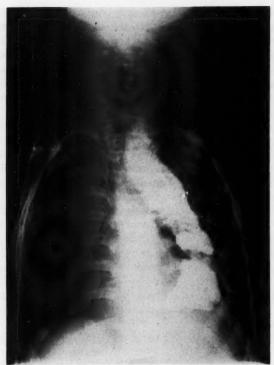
Postoperative roentgenogram of case II, showing position of stomach and no evidence of obstruction at anastomosis which is in the neck. The stomach was empty in one hour.
